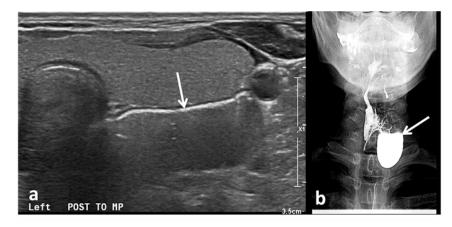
Transverse Ultrasound of a 44-year-old-female (a) shows an inhomogeneous structure posterior to left thyroid lower pole (arrow), containing a linear echogenicity indicating air within a structure with hollow viscus. Frontal pharyngeal view of barium swallow study (b) demonstrating a large left laterally directed pharyngeal pouch arising at C6 level (arrow) indicating a Zenker's diverticulum.
